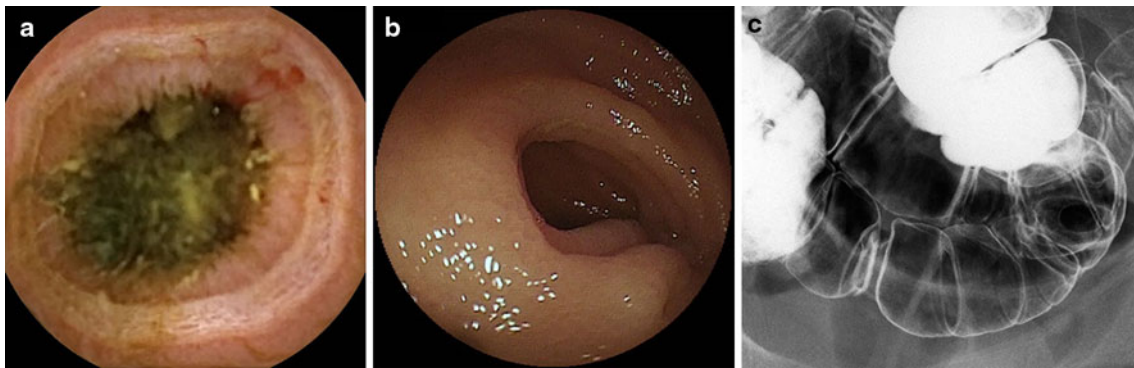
Enteroscopic and radiographic findings of a case of circular ulcers in the ileum. A 78-year-old female who had been diagnosed as rheumatoid arthritis and had been under celecoxib was examined because of anemia. Under VCE (a) and oral BAE (b), multiple
